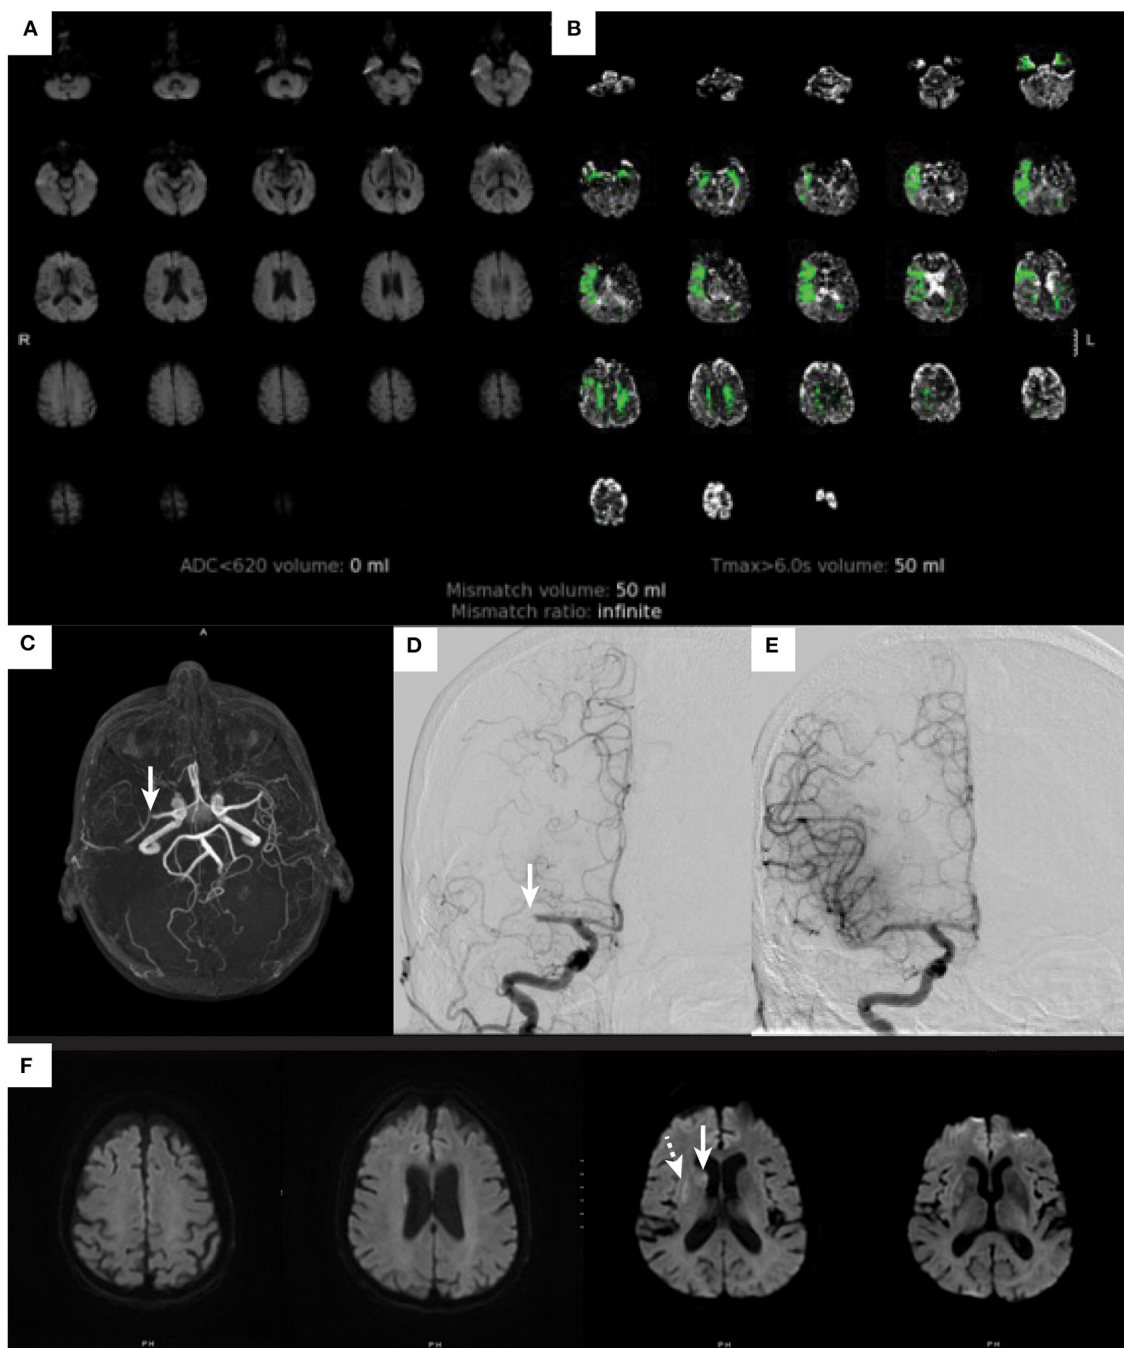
Ischemic stroke in an elderly patients with mild symptoms. An 81-year-old woman with atrial flutter on apixaban, hypertension, hyperlipidemia, and baseline modified Rankin score of 0 developed acute onset left facial droop with dysarthria and left hand weakness. These symptoms lasted for about 20 min and then completely resolved by the time she arrived to the emergency department. On initial examination she had an NIHSS score of 0. She was not treated with IV alteplase due to resolution of symptoms. A diffusion-weighted image (A) does not show any evidence of cerebral infarction ($ADC < 620$ volume 0), and perfusion imaging (B) demonstrates a perfusion deficit within the right MCA territory ($T_{max} > 6$ s volume 50 ml). An MR angiogram [arrow (C)] shows a right M1-MCA occlusion. The patient underwent a cerebral angiogram that identified the right M1-MCA occlusion [arrow (D)], which was successfully treated by thrombectomy with complete revascularization (E). A post thrombectomy diffusion-weighted MRI (F) demonstrates small cerebral infarctions within the caudate (arrow) and putamen (dashed arrow).
